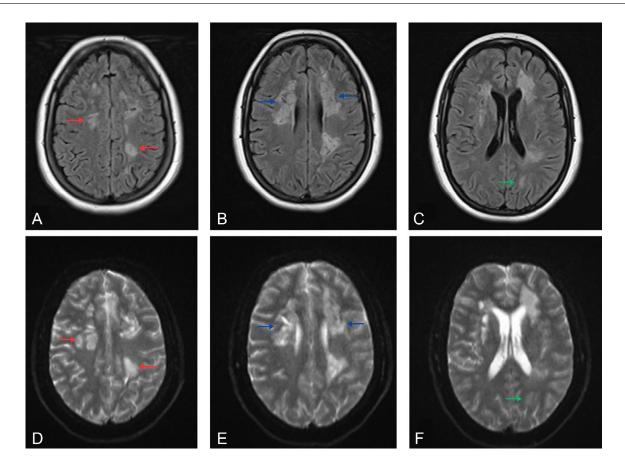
Brain magnetic resonance imaging, axial FLAIR images (A-C) and T2 weighted images (D-F) showing bilateral extensive and confluent supratentorial hyperintensities in the centrum semiovale (red arrows), periventricular white matter (blue arrows) and subcortical white matter (green arrows).
